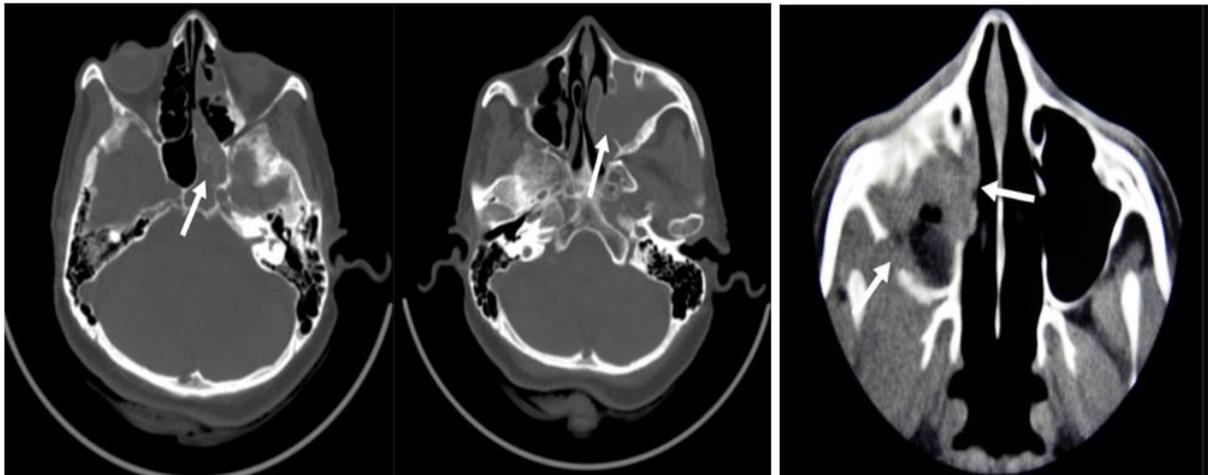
A) Non contrast CT scan axial section shows obliterative soft tissue density thickening involving the left sphenoid sinus with hyperdense contents within. B) Axial plain CT shows soft tissue thickening in left maxillary sinus with erosions of the medial wall and extension of soft tissue into the nasal cavity. C) Non contrast CT shows soft tissue thickening in right maxillary sinus with erosions of medial and lateral walls of maxillary sinus.
